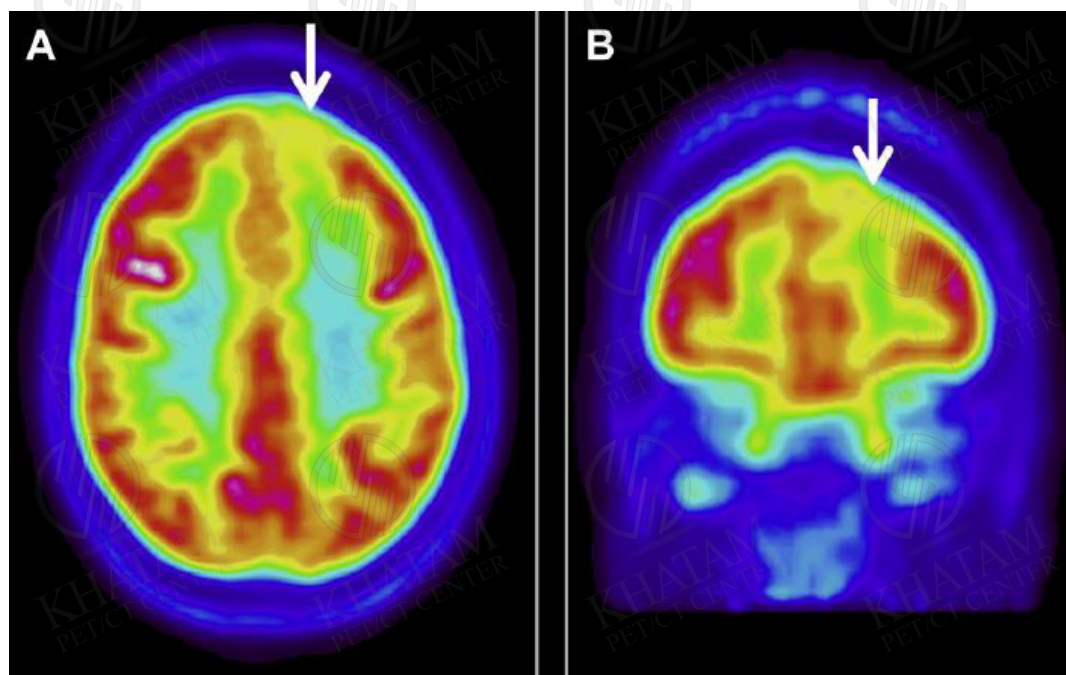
^{18}F FDG PET of a 16-year-old girl with a history of frontal epilepsy refractory to antiepileptic drugs. The recent MRI was unremarkable. Video EEG showed frontal lobe seizures. A hypometabolic cortical region is visible in the left frontal cortex (white arrow) in axial (A) and coronal (B) images. This area was found to be related to the epileptogenic region.
